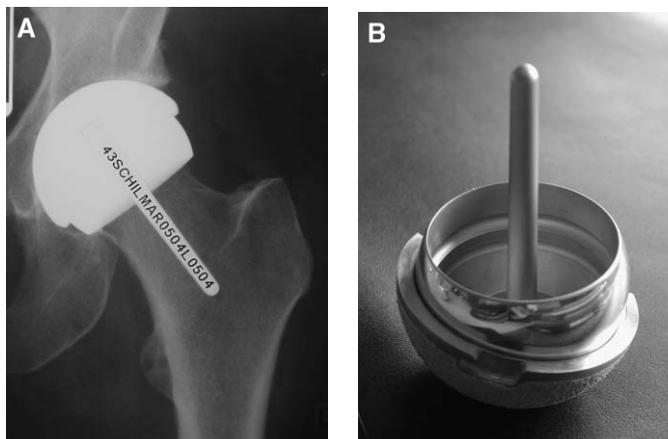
(A) Conserve Plus Thin Shell x-ray, anteroposterior view. (B) Implant.
